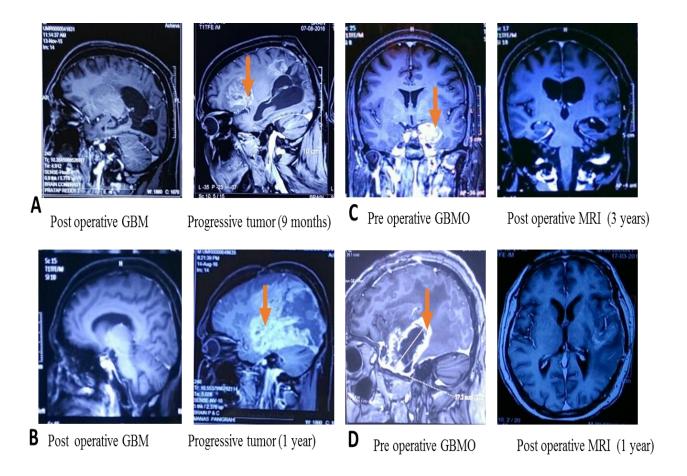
Representative follow up MRI images of pre and post-operative glioblastoma and glioblastoma with oligodendroglial component. A: Post-operative glioblastoma with observed progression after 9 months of resection. B: Post-operative GBM with observed recurrence at occipital lobe after 1 year of resection. C: Pre-operative MRI scan image of occipital glioblastoma with oligodendroglial component and post-operative image taken after 3 years. D: Pre- operative MRI scan image of GBMO and post-operative MRI scan image taken after 1 year. Visible tumor has been marked by an arrow.
